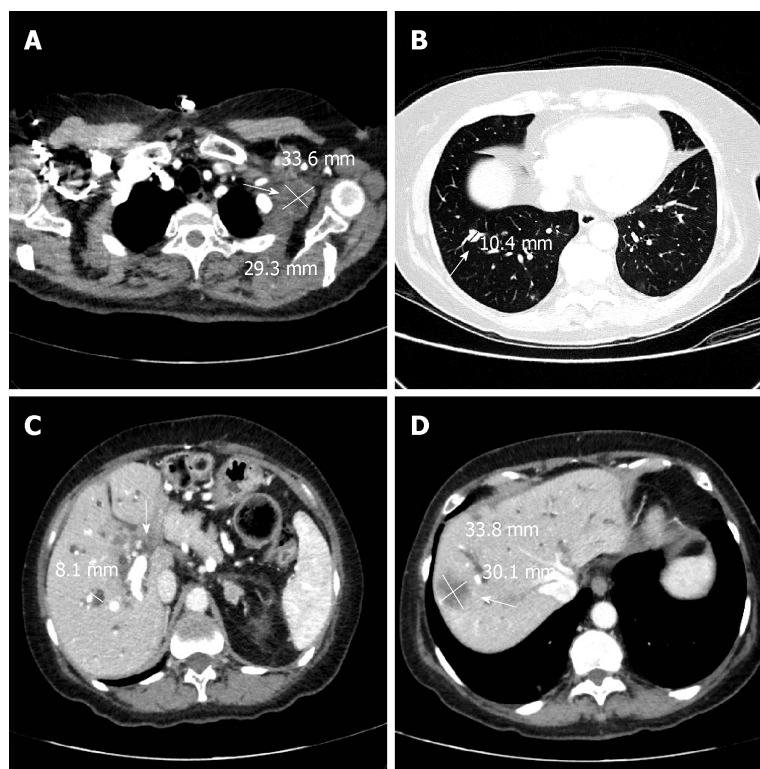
A total body computed tomography scan confirmed the metastases in the lungs, chest, abdominal lymph nodes, liver and hepatic hilar area. A: Arrow showing pathological lymphadenopathy in the left axilla (34 mm × 29 mm); B: Arrow showing secondary lesion of the pulmonary parenchyma in the lower right lobe (10 mm); C: Arrow showing pathological tissue enveloping the hepatic hilum; dilated intrahepatic bile ducts in right lobe (8 mm); D: Arrow showing secondary lesion to the VIII segment of the liver.
